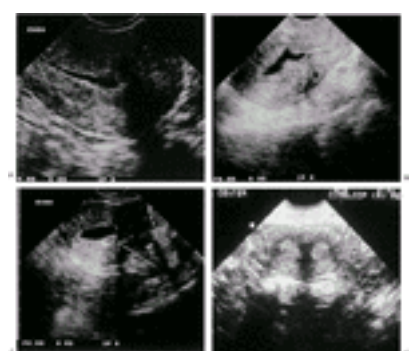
Saline infusion sonography (SIS) evaluation of the uterine cavity. A: SIS demonstrating a normal uterine cavity. B: SIS demonstrating an intrauterine mass. C: SIS demonstrating a localized posterior wall thickening. D: Bicornuate or septate uterus visualized prior to instillation of saline.
